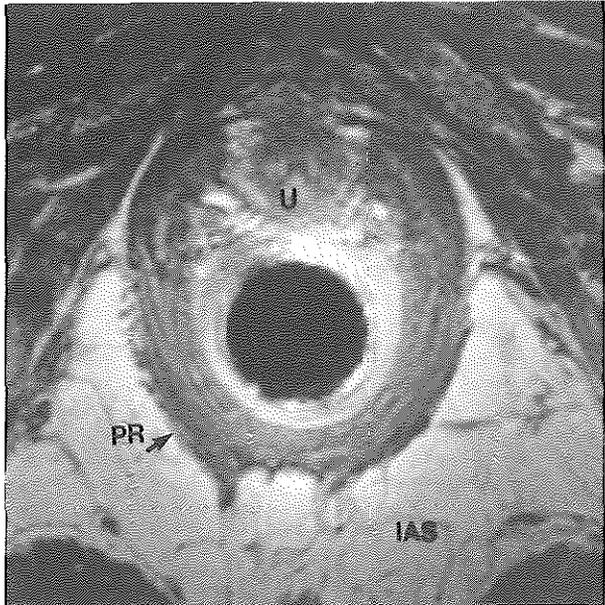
Endoanal MRI, axial proton density weighted GRE, showing a normal puborectalis muscle (PR). Ischioanal space (IAS). Urethra (U).
